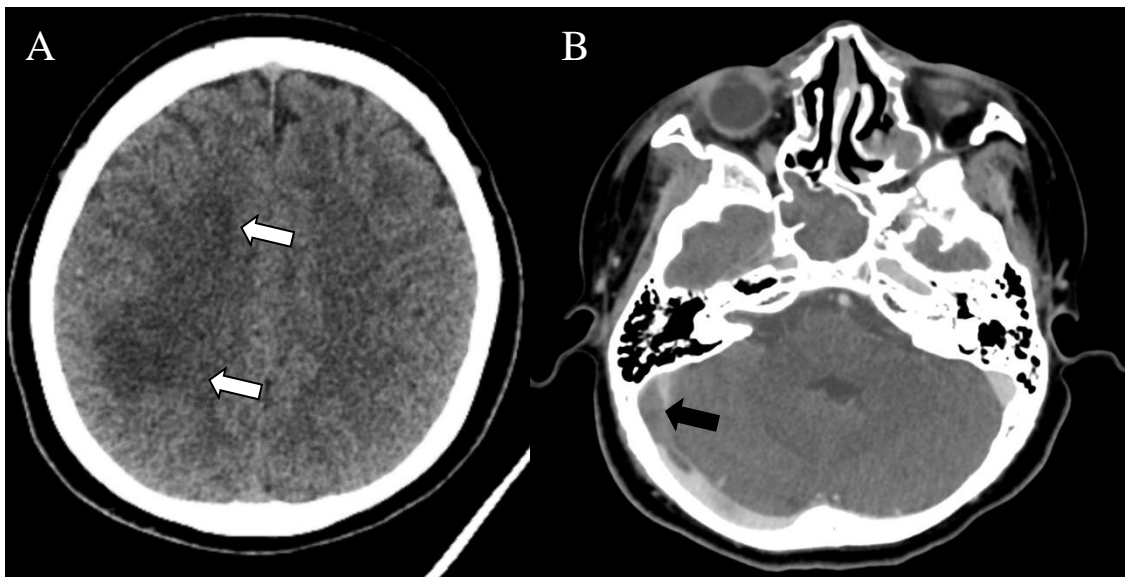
CT Brain on Day 13 of trauma showed new ill-defined hypodensities at right frontal and parietal lobes (white arrows) suggestive of recent infarctions with suspicious hypodensity in right transverse and sigmoid sinuses (not shown) (A). CT venography brain performed confirmed the right transverse and sigmoid sinuses thrombosis (Black arrow, B).
